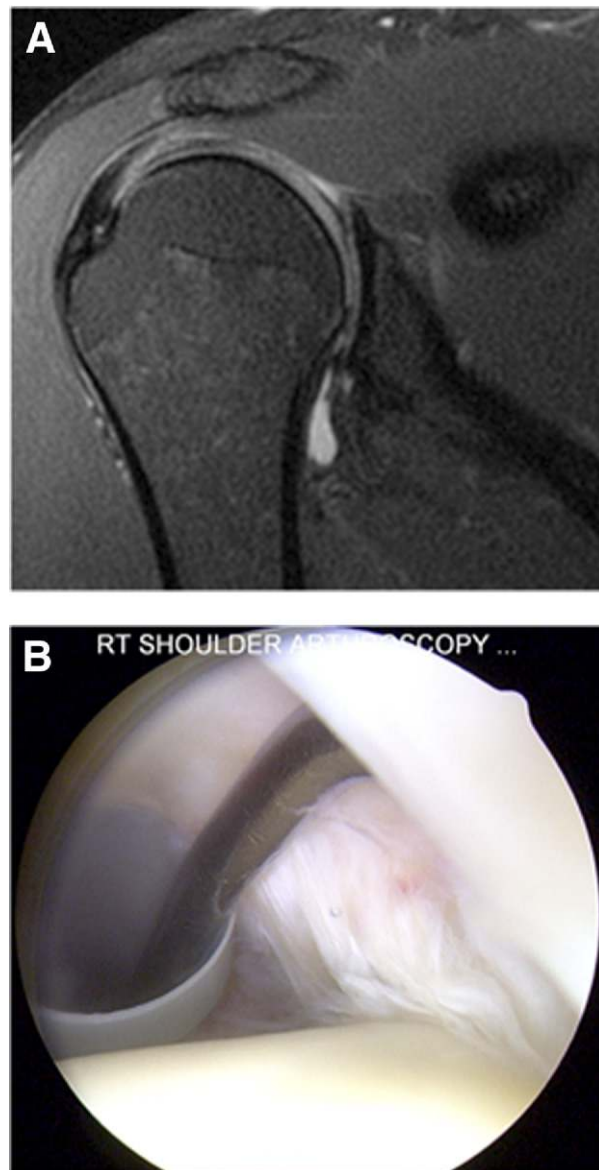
(A) Coronal magnetic resonance image and (B) intra-articular appearance with patient in beach-chair position of articular-sided partial-thickness tear of supraspinatus in 50-year-old right hand-dominant man with 7 months of activity-related right shoulder pain.
